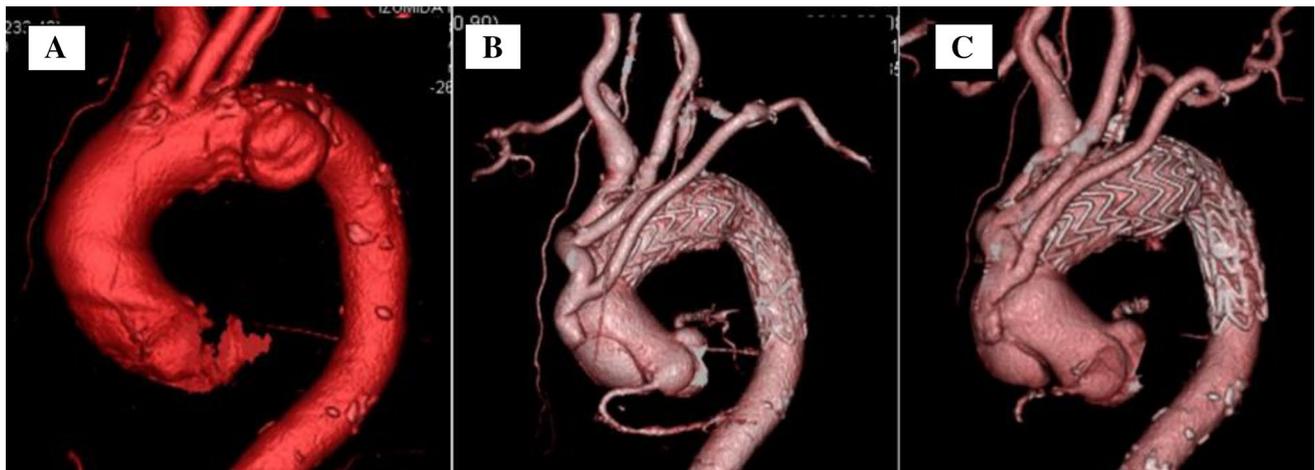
Three-dimensional computed tomography findings for Case 1 showing a the distal arch aneurysm before the initial procedure. b A new type A aortic dissection with ascending aorta diameter 54 mm
